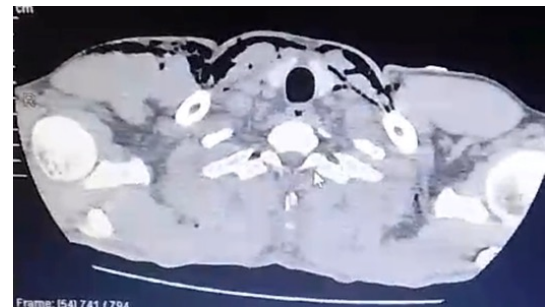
Surgical emphysema seen on CT chest.
